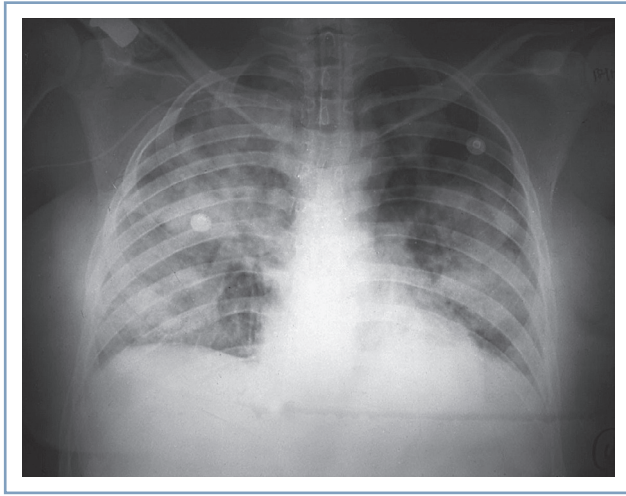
Radiographic changes after pulmonary aspiration of gastric contents in pregnancy.
